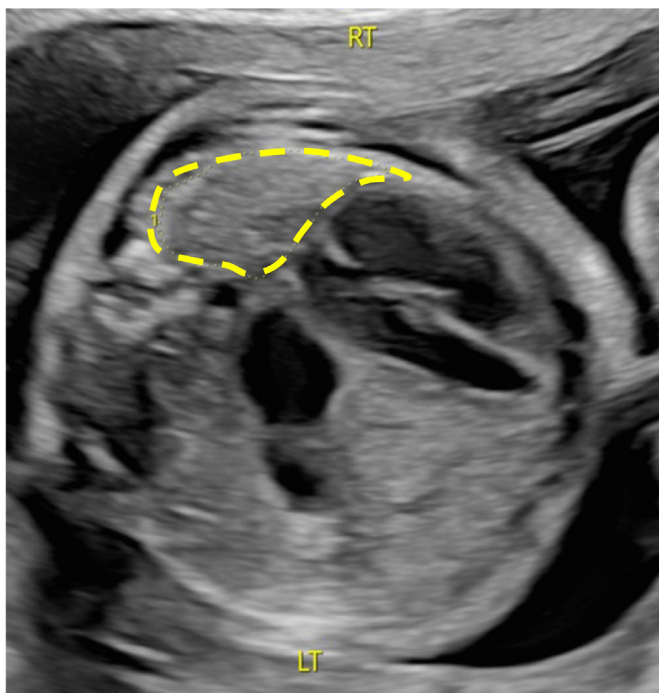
Axial section of the fetal chest demonstrating sonographic measurement of the right (RT) lung area using the 'trace' method in a fetus with left CDH. The lung area is obtained on a well-optimised cross-section of the fetal chest at the level of the four-chamber view of the heart, by manually tracing the lung perimeters. The lung area is combined with the fetal head circumference to obtain an observed-to-expected lung-to-head ratio. CDH, congenital diaphragmatic hernia; LT, left.
